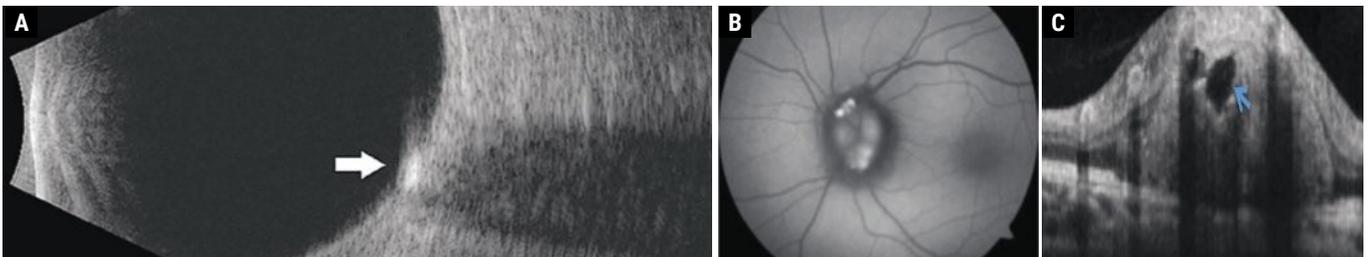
(a) Disc drusen seen as hyperreflective deposit on B-scan ultrasonography. (b) Disc drusen exhibiting hyperautofluorescence on FAF photography. (c) Disc drusen seen as a signal-poor core with hyperreflective borders on enhanced-depth imaging OCT.
